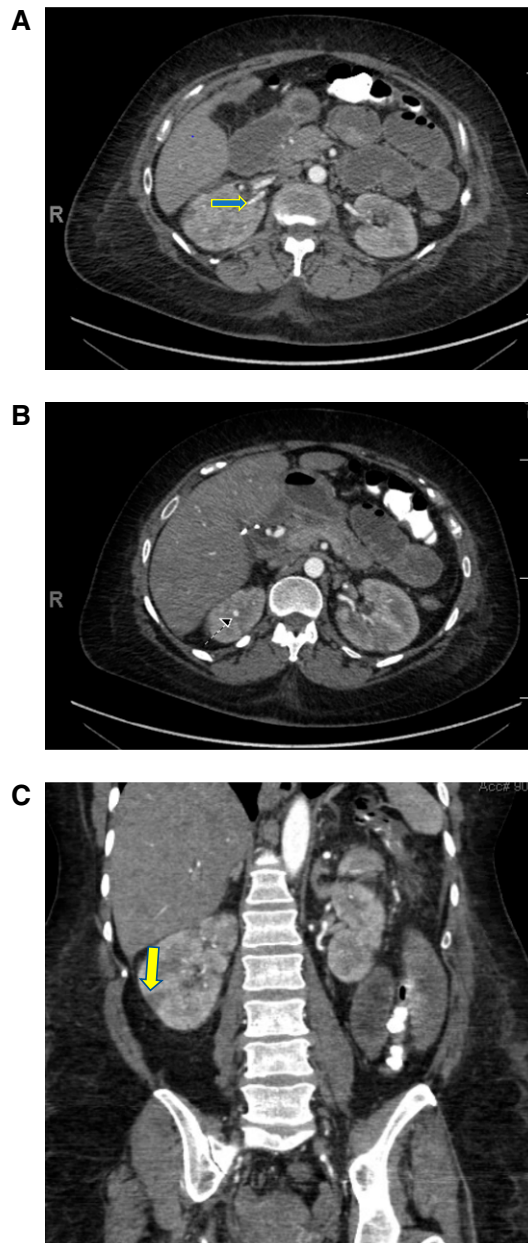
Computerized tomography (CT) scan images. (A) Computed tomography image of the abdomen showing beading of the left renal artery (arrow). (B) Computed tomography image of the abdomen showing pseudoaneurysms (arrow). (C) Computed tomography image of the abdomen showing wedge-shaped renal infarcts (arrow).
